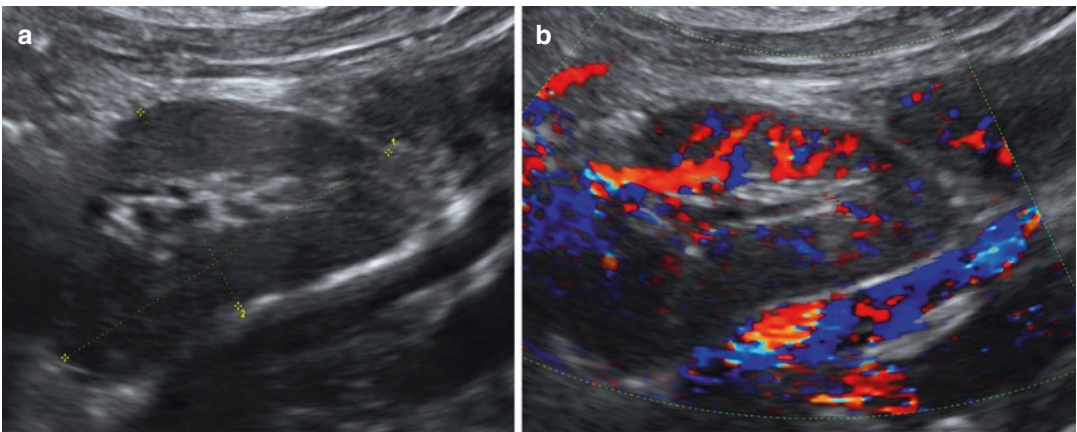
Non-ovarian pathology. (a) A gray-scale image of a pelvic kidney mimicking an adnexal mass. (b) Highly organized distribution of vascular supply to the kidney is shown on color Doppler evaluation
